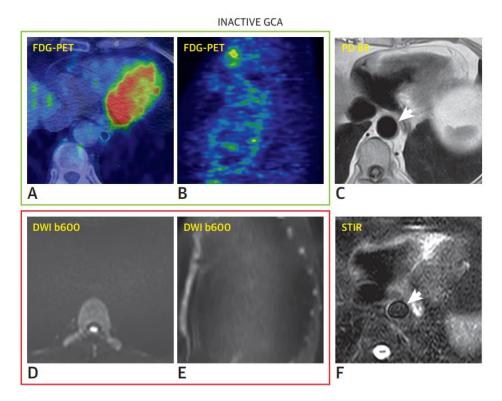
Patient in ongoing treatment, GCA clinically inactive. Negative FDG-PET/CT imaging test. A. Axial FDG-PET/CT, B. Sagittal FDG-PET/CT; MRI imaging with no affectation; C. Arterial wall thickness is not increased, D. Axial, E. Sagittal reconstruction aortic wall not detectable, F. No pathological changes. Ironi G. et al. (2018) ⁽¹⁸⁾.
